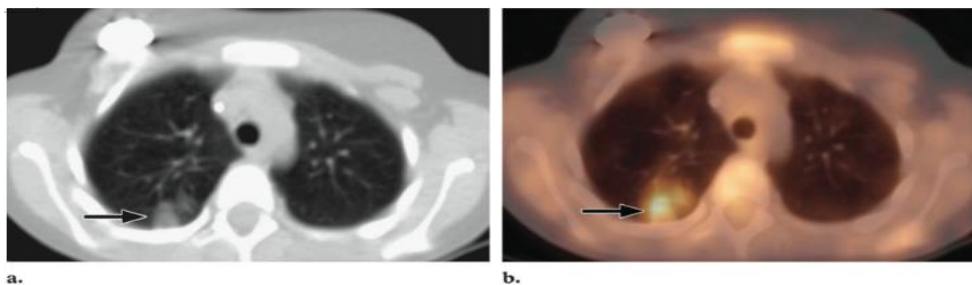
Pneumonia in an 8 year old boy with history of neuroblastoma, fever and cough. (a) Transverse CT scan (lung window) shows an area of infection in the right lung (arrow). (b) Transverse fused ^{18}F FDG PET/CT image shows markedly increased uptake in the right lung (arrow), a finding that corresponds to the area of infection. At follow-up imaging performed after a course of antibiotic therapy, the infection had resolved. (39).
